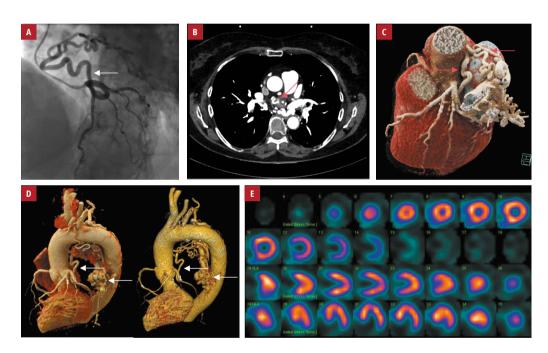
A – coronary angiography showing the fistulous path originating in the circumflex artery (arrow); B – axial computed tomography angiography at the level of large vessels showing tortuous coronary fistula (arrow); C – a 3-dimensional reconstruction of computed tomography angiography; D – a 3-dimensional reconstruction of computed tomography angiography showing the long fistulous path to the bronchial arteries (arrows); E – single-photon emission computed tomography showing normal perfusion at stress
